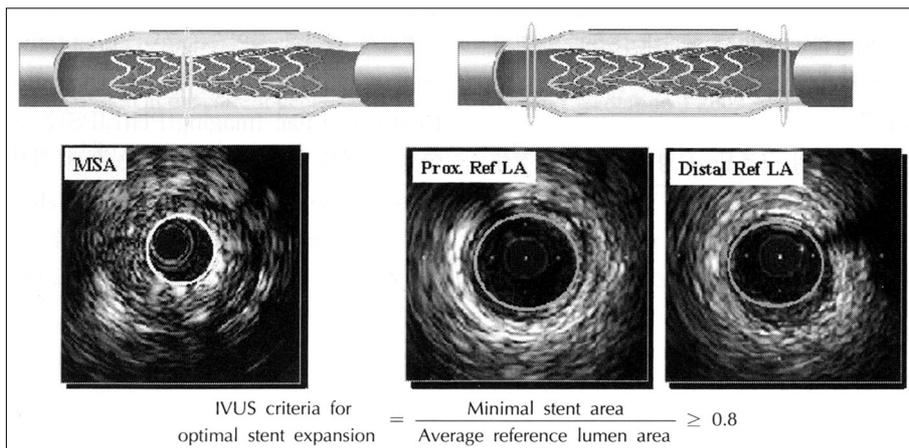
Intravascular ultrasound criteria for optimal stent expansion. MSA : minimal stent area, Prox. Ref LA : proximal reference lumen area, Distal Ref LA : distal reference lumen area, IVUS : intravascular ultrasound.
